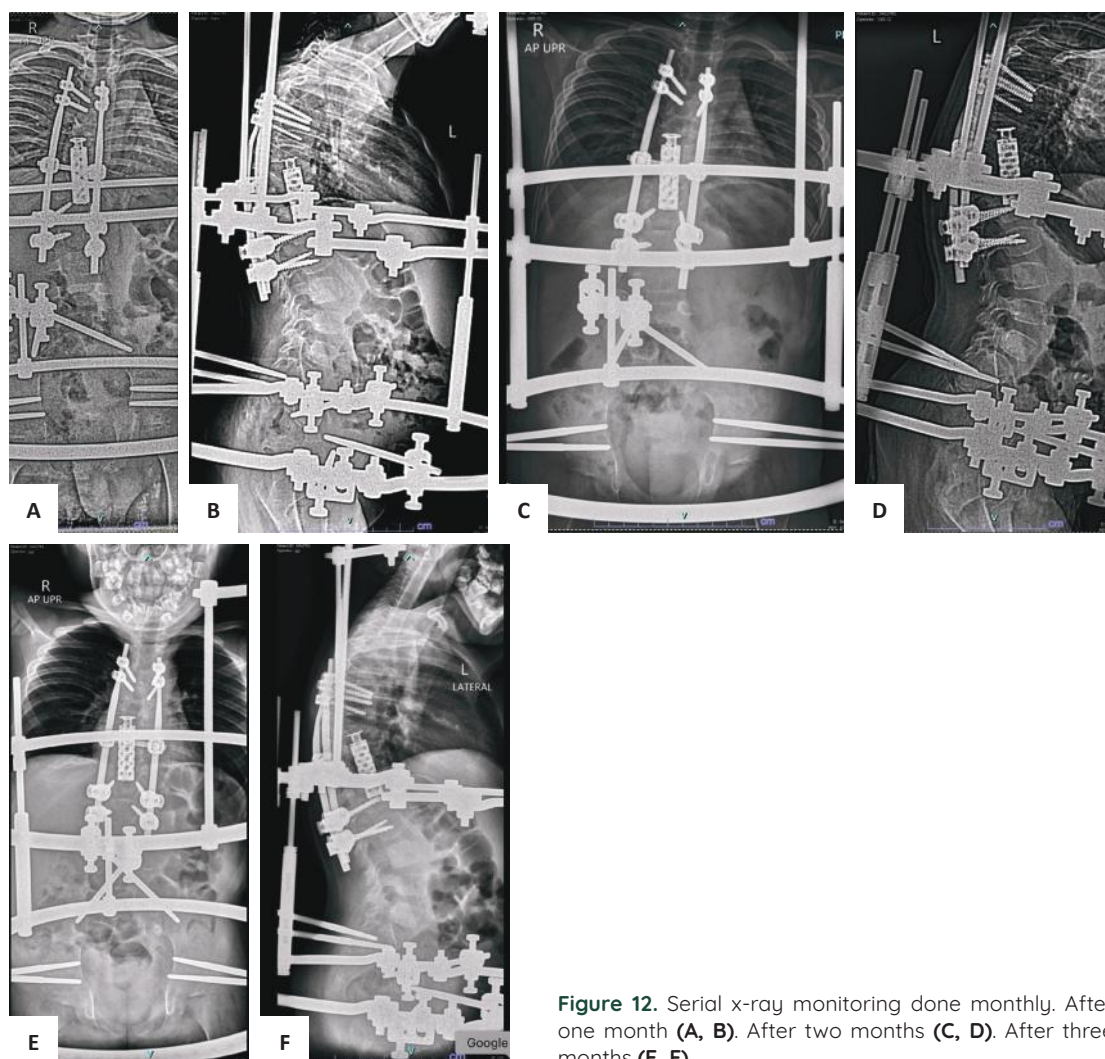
Serial x-ray monitoring done monthly. After one month (A, B). After two months (C, D). After three months (E, F).
